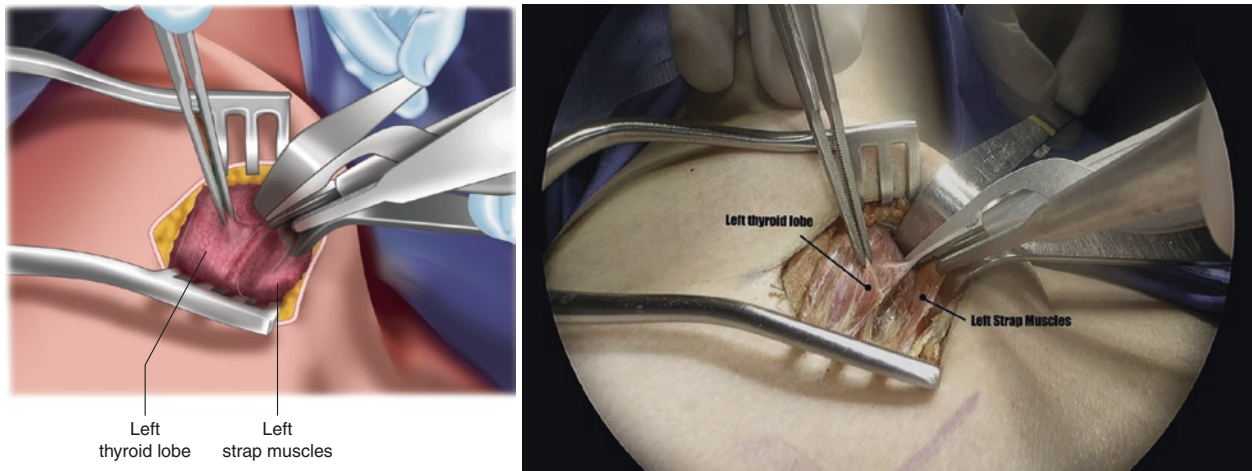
Mobilization of strap muscles. Blunt dissection of the left strap muscles is performed to achieve their complete mobilization laterally and the exposure of the entire left thyroid lobe. Attachments of the strap muscles to the thyroid capsule are divided using an ultrasonic energy device
